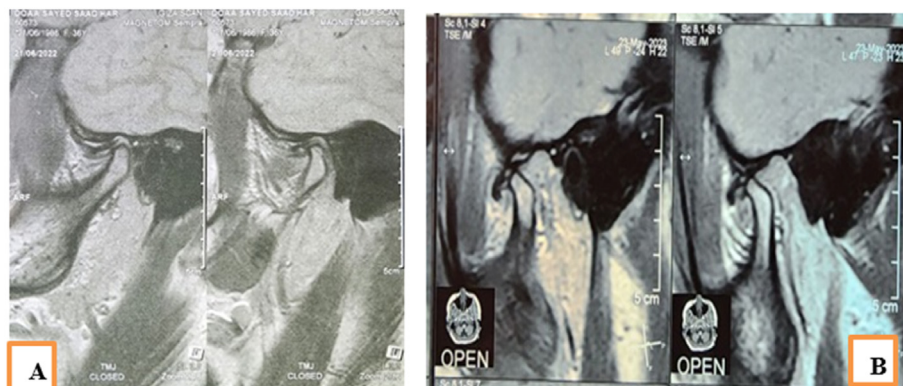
(A) Preoperative T1 MRI show closed cut of temporomandibular joint shows flattening in the condyle, osteophyte and anterior Disc displacement. (B) Postoperative T1 MRI shows right open cut shows flattening in condyle, osteophyte.
